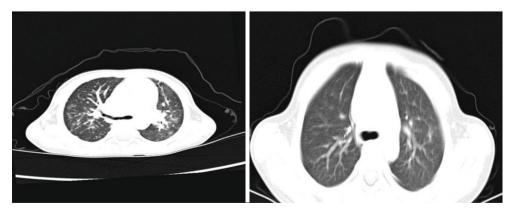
Case 3. Lung CT showed multiple patchy high-density shadow with blur edge in both lungs, and air bronchogram.
